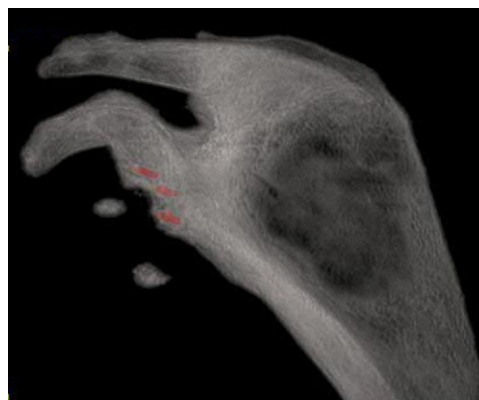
Three-dimensional computed tomography scan of glenoid with metallic enhancement technique. The fracture was observed between the middle and inferior anchors at the level of the drill holes for the 2 anchors.
